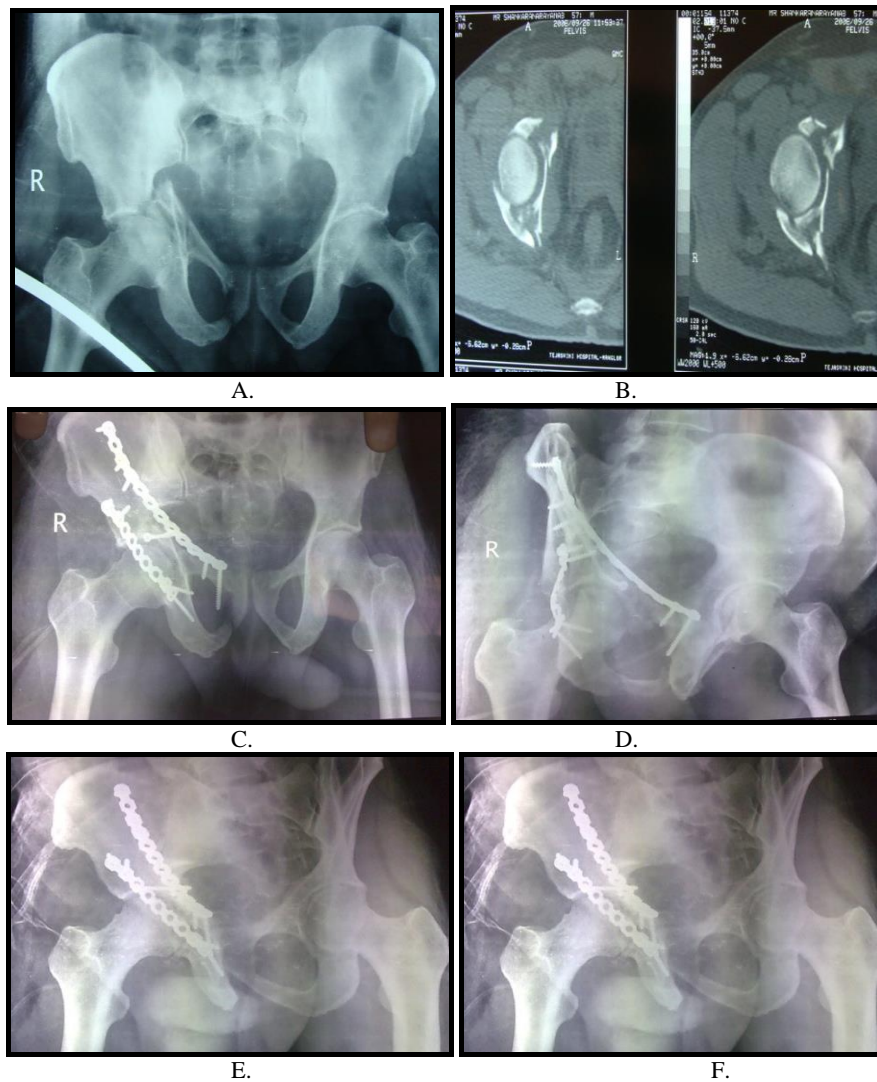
52yrs old male with H/O RTA. Pre-operative radiograph (a) and CT scan (b) showing 'T' shaped fracture. It was operated on 6th day post injury with both anterior and posterior approaches. Post-operative radiographs AP view (c) and Judet views (d)
